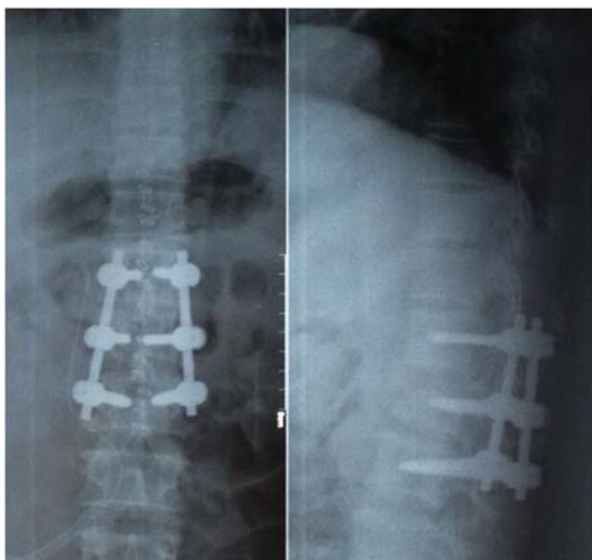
Post operative X-ray showing fixation implants in situ
